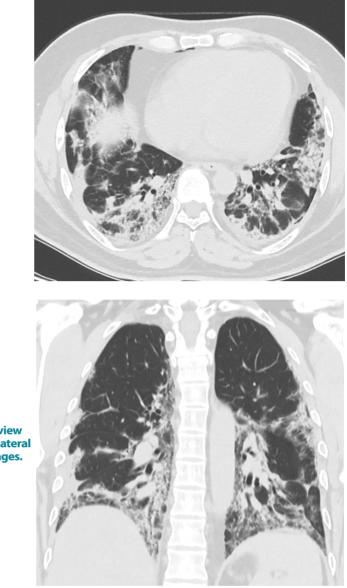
CT chest showing extensive COVID changes.
